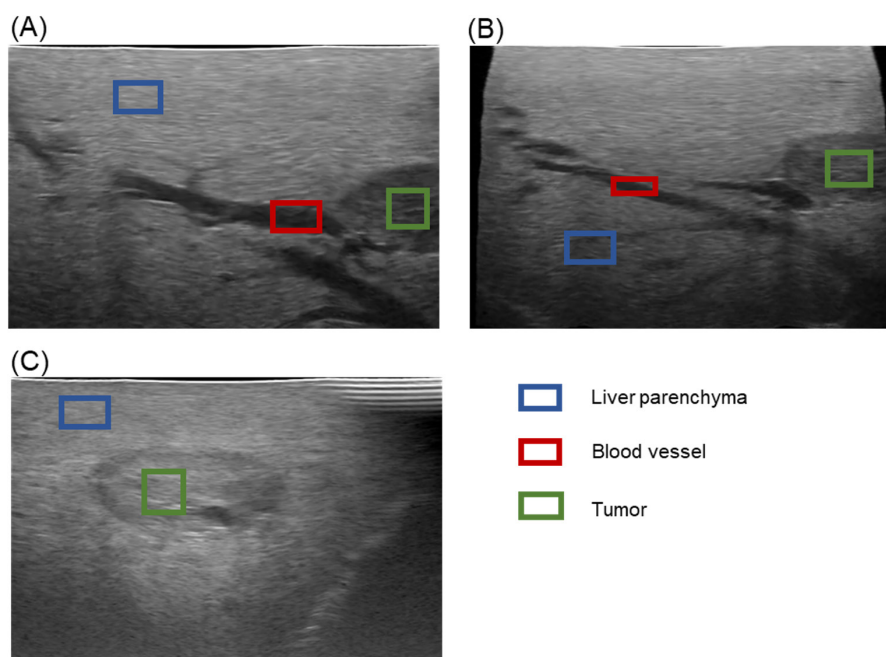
Regions of the liver parenchyma, blood vessels, and a tumor for scaling factor comparisons using the PLSN model. Vertical pixel information within each rectangle is used for comparison. Each region contains 50 ultrasound signals.
